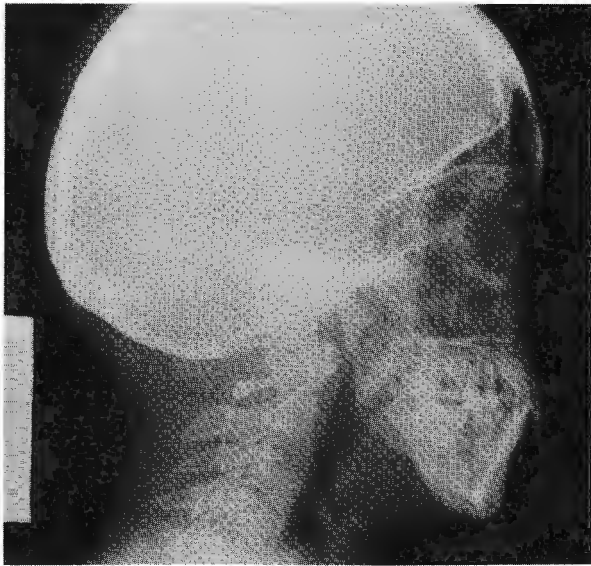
Lateral x-ray of proband's mother showing steep mandibular angle.
